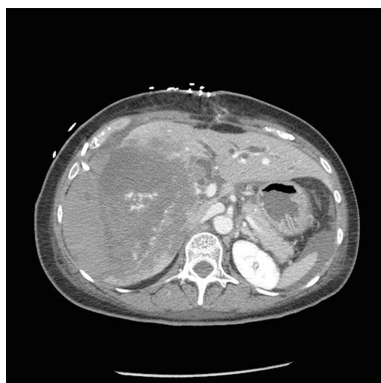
Computed tomography scan show a massive intrahepatic hematoma involving the right hepatic lobe and segment IV.
